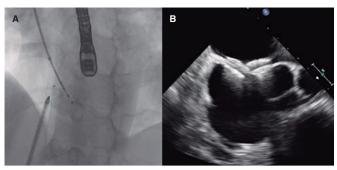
A: fluoroscopic image of the closure of a multi-fenestrated atrial septal defect with 2 devices guided by fluoroscopy, transesophageal echocardiography, and intracoronary ultrasound. B: transesophageal echocardiography, mid-esophageal plane, showing the 2 implanted closure devices.
